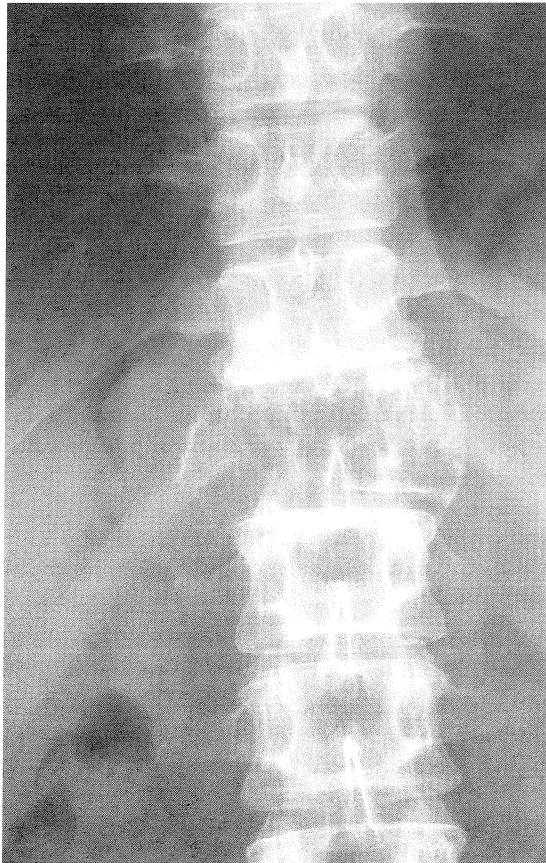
Frontal radiograph of the thoraco-lumbar region.
